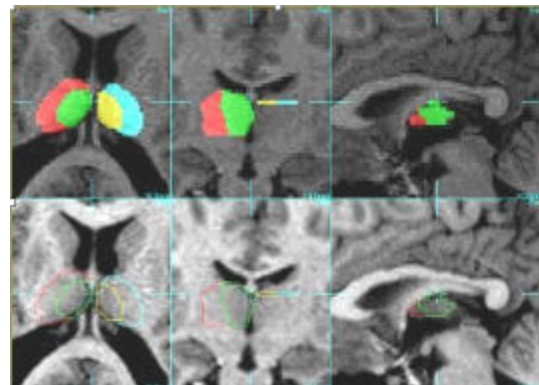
Example anatomical boundaries used to define the thalamus and to subdivide the thalamus into lateral and medial regions, based on each individual's MRI scan. Red=right lateral thalamus, green=right medial thalamus, blue=left lateral thalamus, yellow=left medial thalamus. In the top panels, the regions are filled in with color; in the bottom panels the same regions are outlined with thin colored lines.
